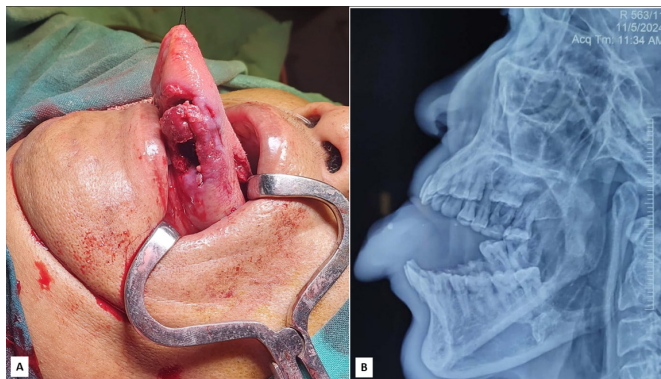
(A) Intra-operative picture showing tongue after exploration and (B) intra-operative X-ray showing residual foreign body in tongue
